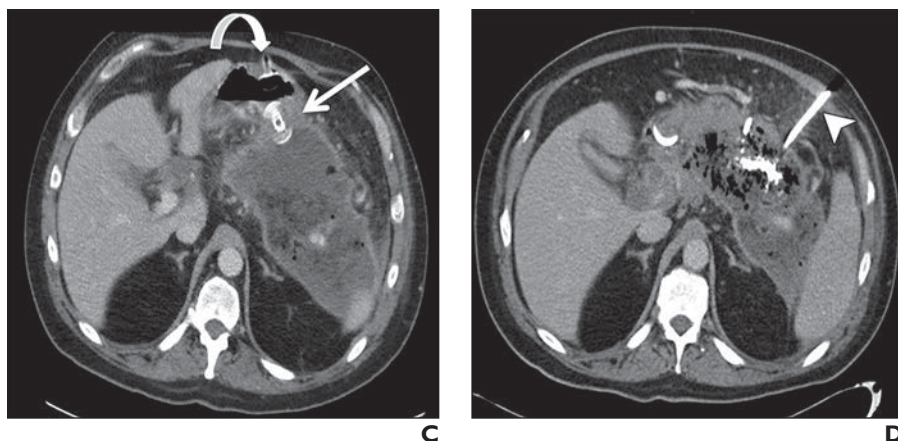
(continued)—48-year-old man with severe abdominal pain. C and D, Axial CT images obtained 2 weeks after multiple minimally invasive drainage procedures show transmural lumen-apposing stent (straight arrow, C), percutaneous gastric tube (curved arrow, C), and percutaneous drainage catheter (arrowhead, D). Procedures failed to adequately drain necrotic collection. Patient eventually underwent open surgical débridement.
